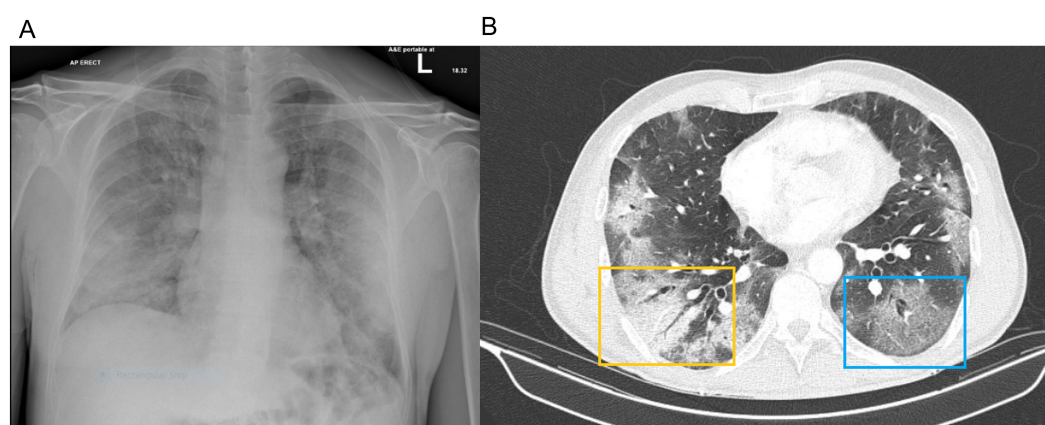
Examples of radiological changes in COVID pneumonia. (A) CXR in a patient with COVID pneumonia showing ground glass and consolidation. (B) Corresponding CT patient with COVID pneumonia showing right-sided consolidation with air bronchogram (yellow box) and left-sided ground glass (blue box) changes—source author. L, left.
